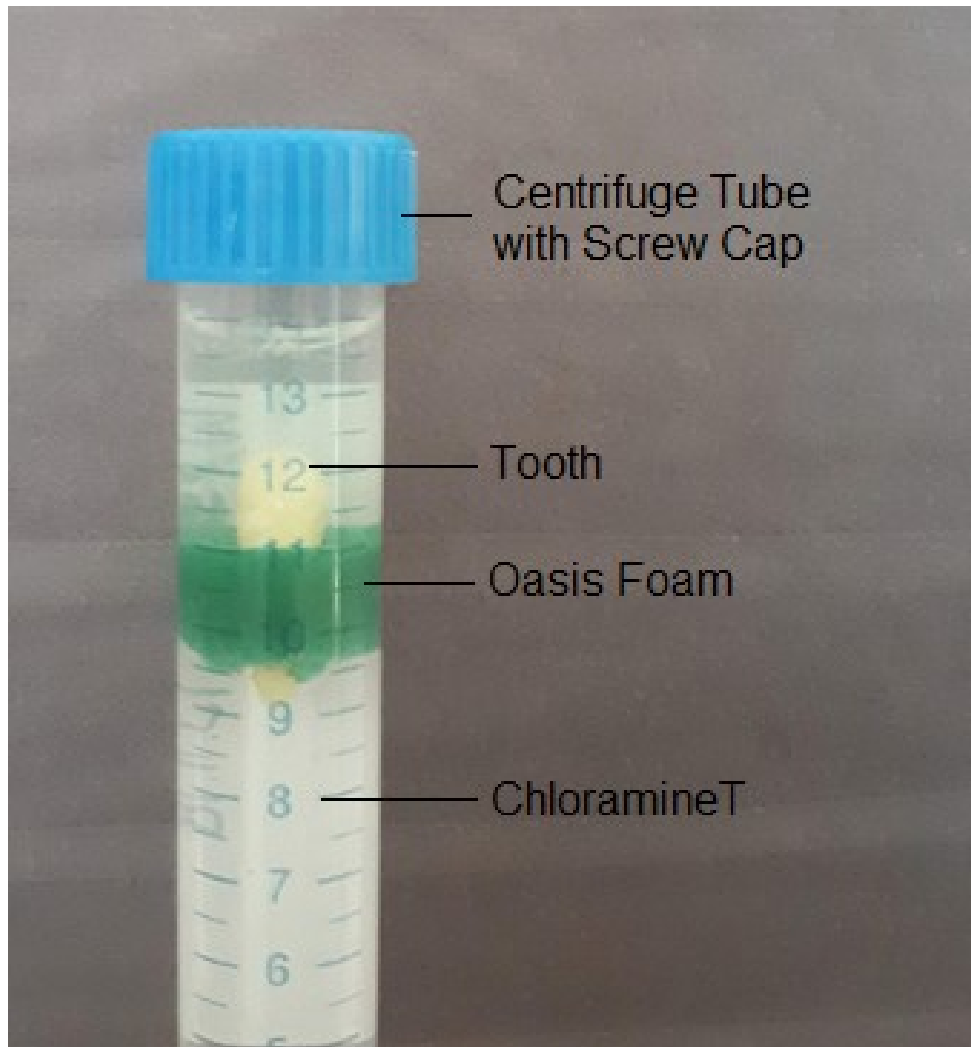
Experimental setup for creating μ -CT images. Individual teeth were held in place with Oasis foam in a screw-capped centrifuge tube. The centrifuge tube was filled with 1% chloramine-T solution.
